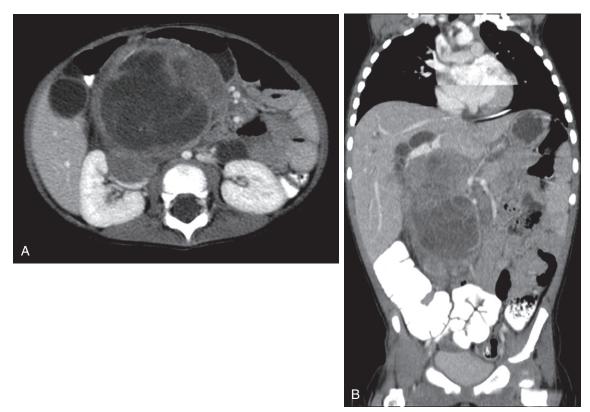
Neuroblastoma. A, Axial CT of an abdominal mass in a child with neuroblastoma. B, Coronal CT of a patient with abdominal neuroblastoma, demonstrating the encasement of vital structures and vessels within the tumor.
